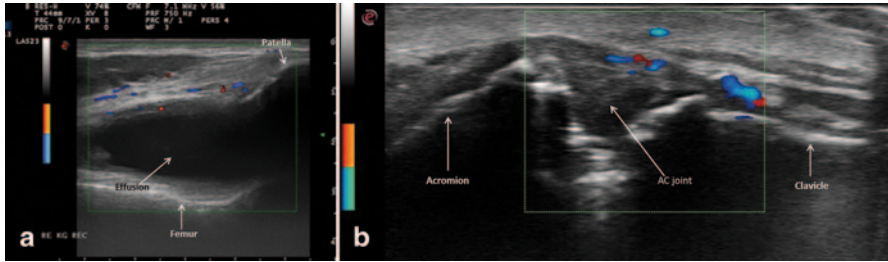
a Sonographic B-mode image with power Doppler of the knee joint showing effusion in the joint with synovial hypertrophy and enhanced vascularity. b Sonographic B-mode image with power Doppler of the acromioclavicular joint showing synovitis with enhanced vascularity
